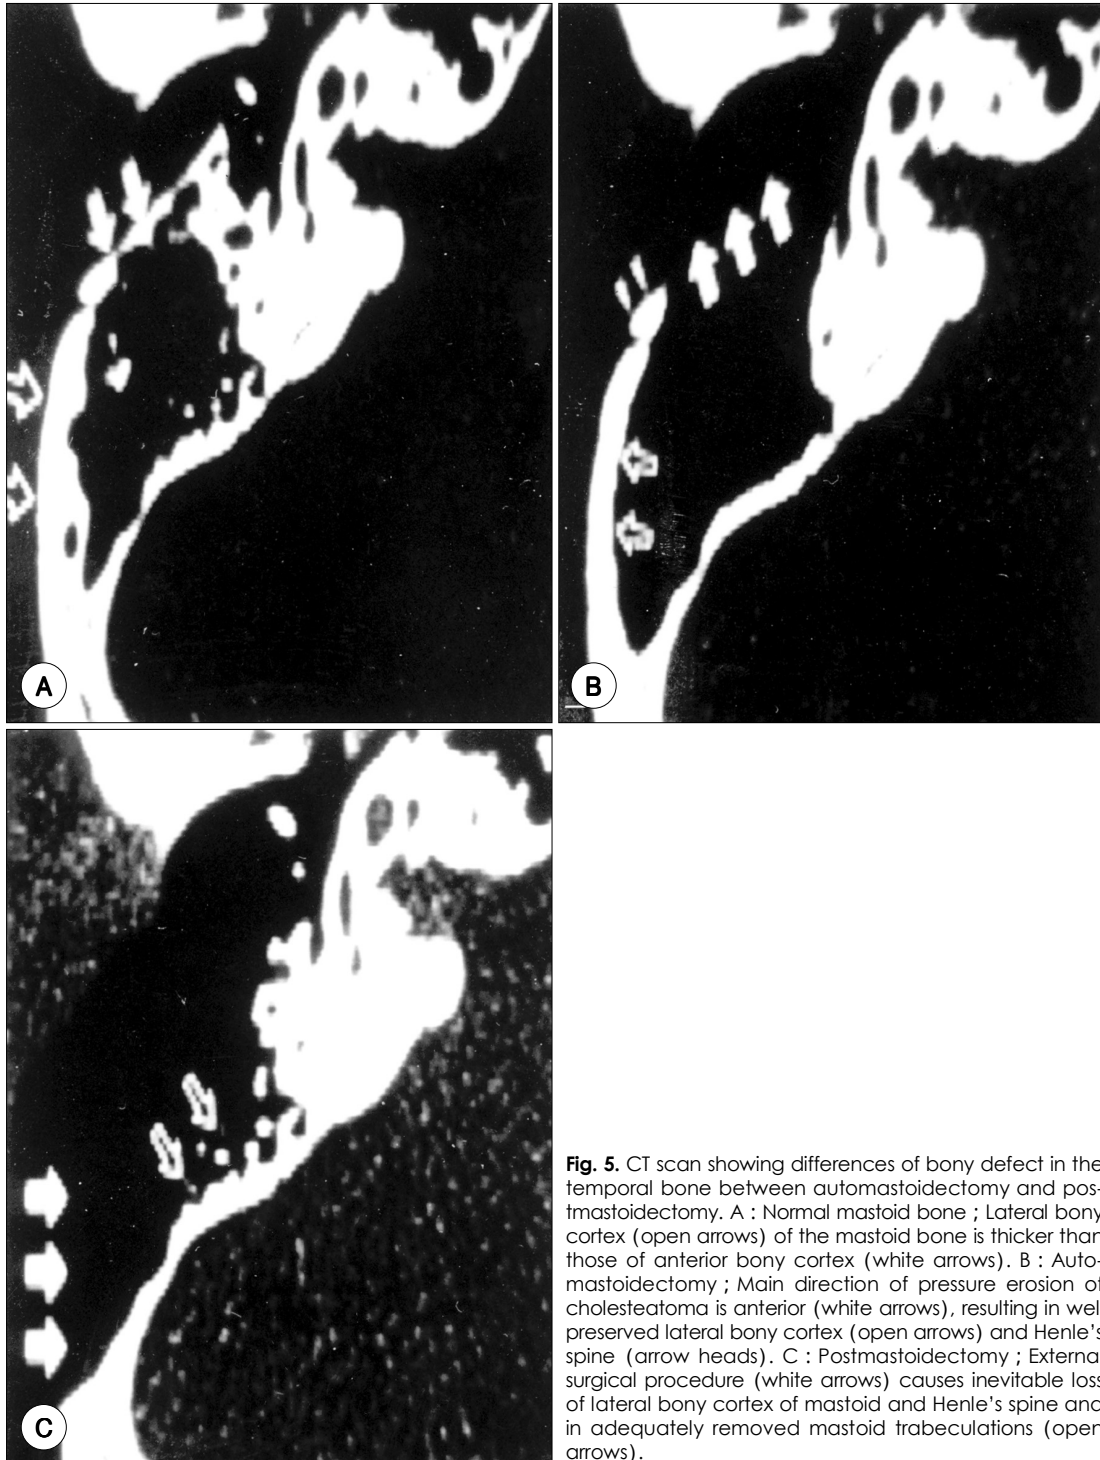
CT scan showing differences of bony defect in the temporal bone between automastoidectomy and postmastoidectomy. A : Normal mastoid bone ; Lateral bony cortex (open arrows) of the mastoid bone is thicker than those of anterior bony cortex (white arrows). B : Automastoidectomy ; Main direction of pressure erosion of cholesteatoma is anterior (white arrows), resulting in well preserved lateral bony cortex (open arrows) and Henle's spine (arrow heads). C : Postmastoidectomy ; External surgical procedure (white arrows) causes inevitable loss of lateral bony cortex of mastoid and Henle's spine and in adequately removed mastoid trabeculations (open arrows).
